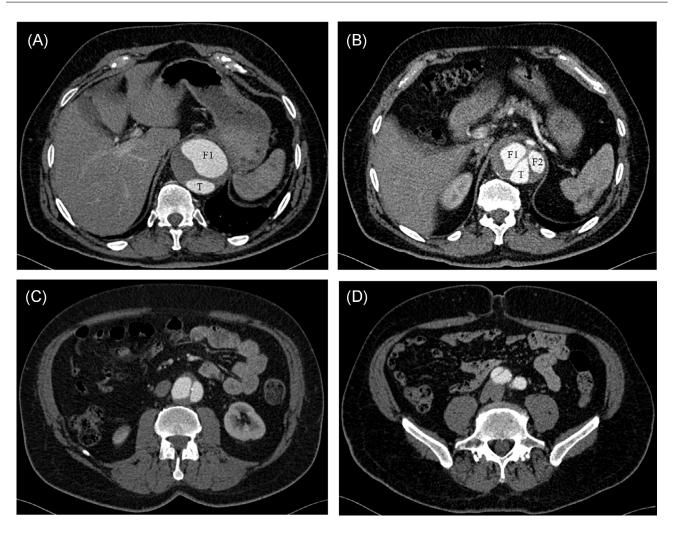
Axial CT angiography images showing a type B thoraco-abdominal aortic dissection at different levels (A) Beginning of the aortic dissection in the descending aorta with 2 lumens: posterior true lumen (T) and anterior partially thrombosed false lumen (F1). (B) Appearance of a second false lumen creating the 'Mercedes Benz' sign: true lumen on the posterior and left side (T) and false lumens anterior and from either side (F1 and F2). (C) Disappearance of the second false lumen in the abdominal aorta. Note the displacement of atherosclerotic calcifications into the lumen. (D) Extension of the intimal flap to the right common iliac artery.
